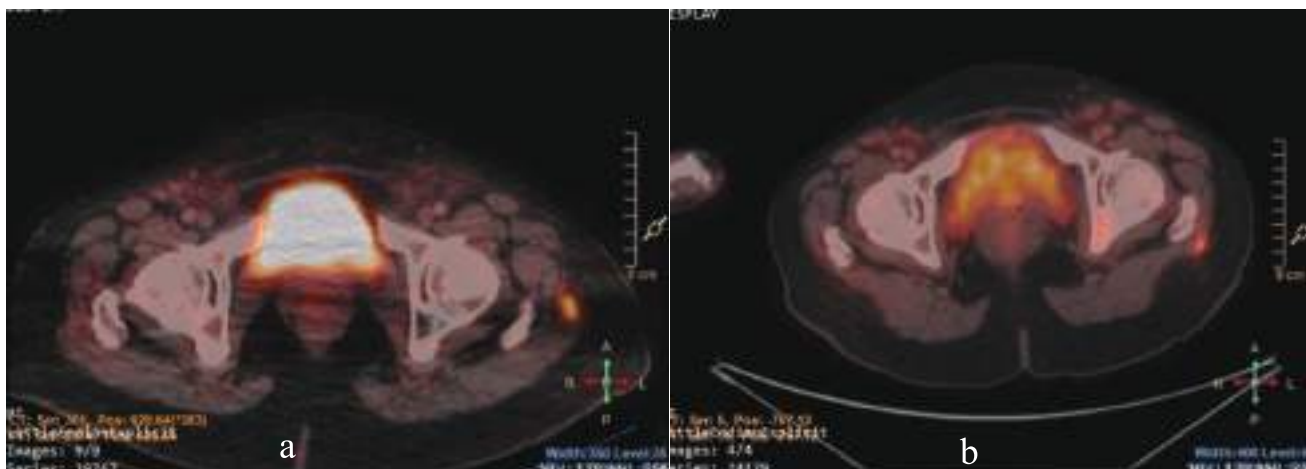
Transaxial fusion F-18 FDG PET-CT images showing hypermetabolic lesion in gluteus muscle (a) which regressed metabolically and morphologically in follow up scan (b).
